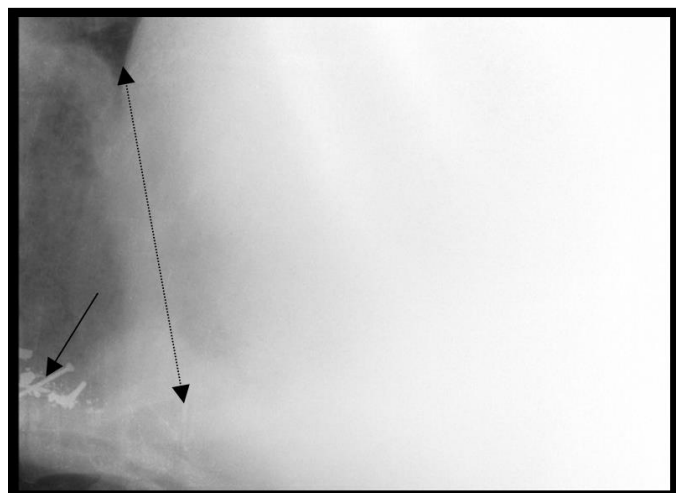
Radiograph showing DH with nails in reticulum
